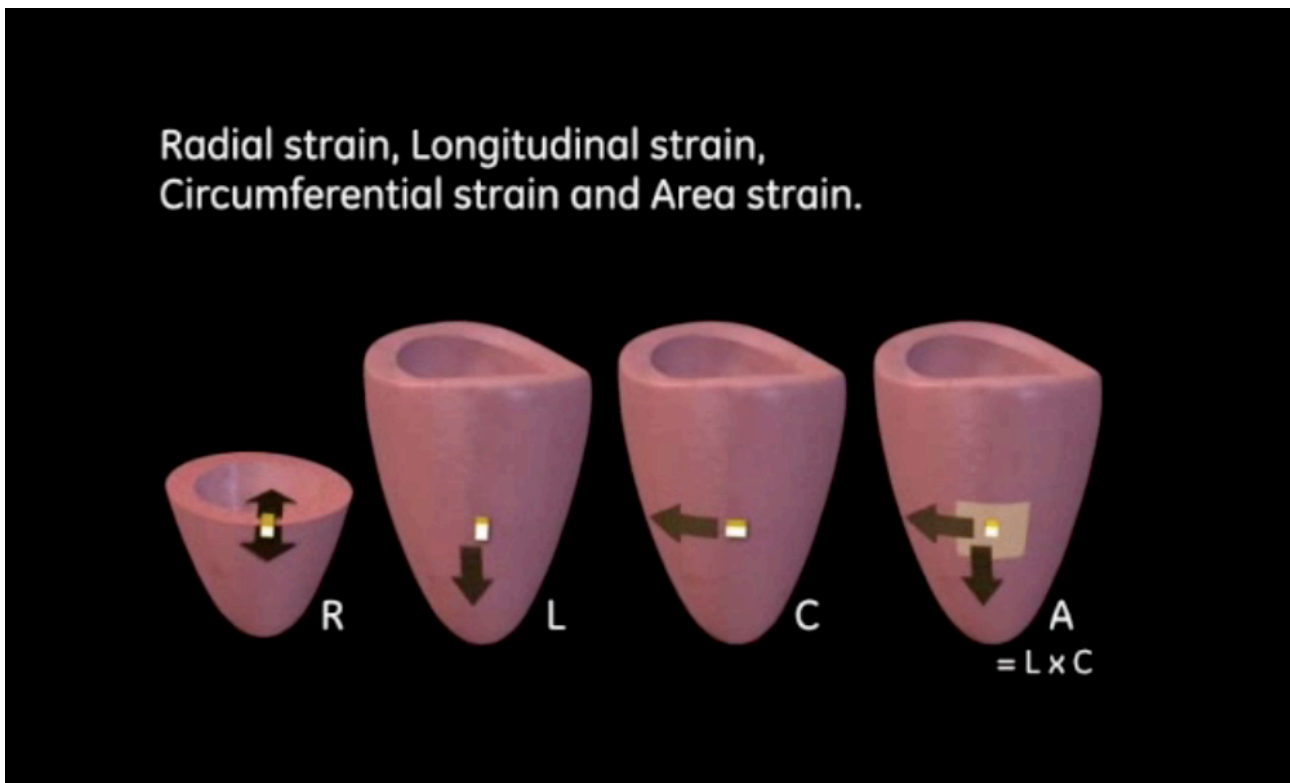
Left ventricular myocardial strain parameters measured by 3D speckle-tracking echocardiography using 4D AutoLVQ software. *Courtesy of GE Vingmed*
